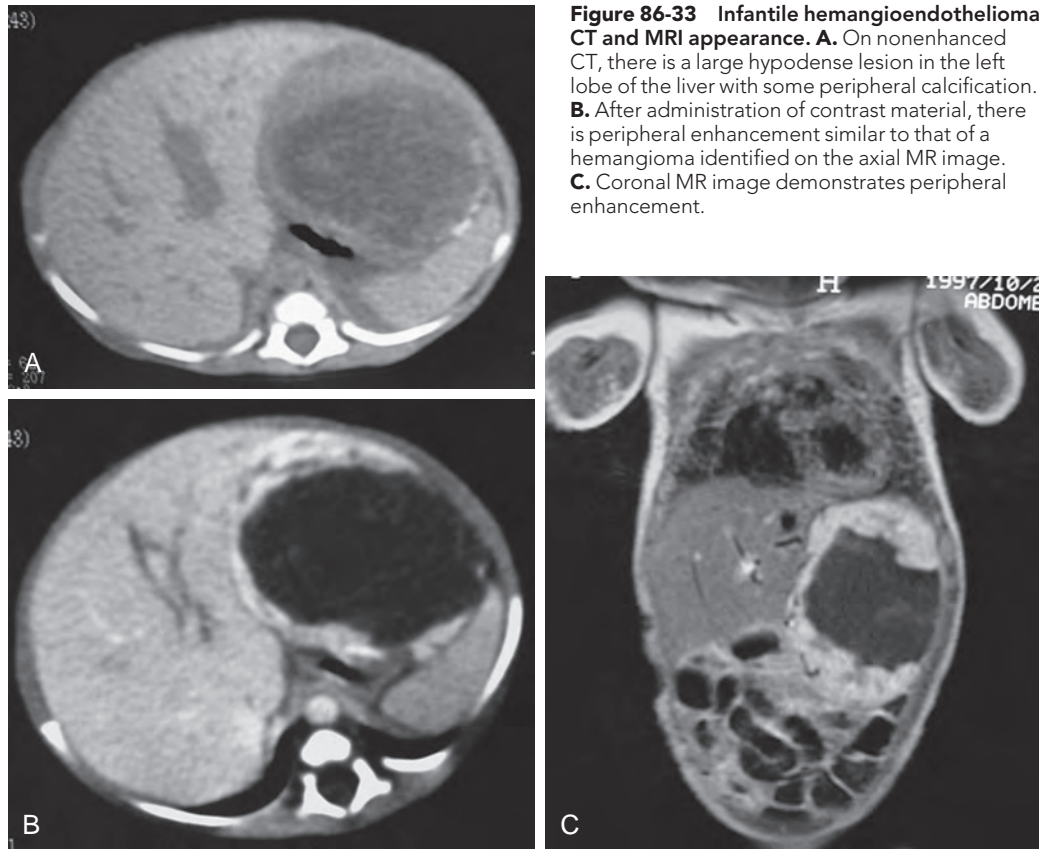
Infantile hemangioendothelioma: CT and MRI appearance. A. On nonenhanced CT, there is a large hypodense lesion in the left lobe of the liver with some peripheral calcification. B. After administration of contrast material, there is peripheral enhancement similar to that of a hemangioma identified on the axial MR image. C. Coronal MR image demonstrates peripheral enhancement.
